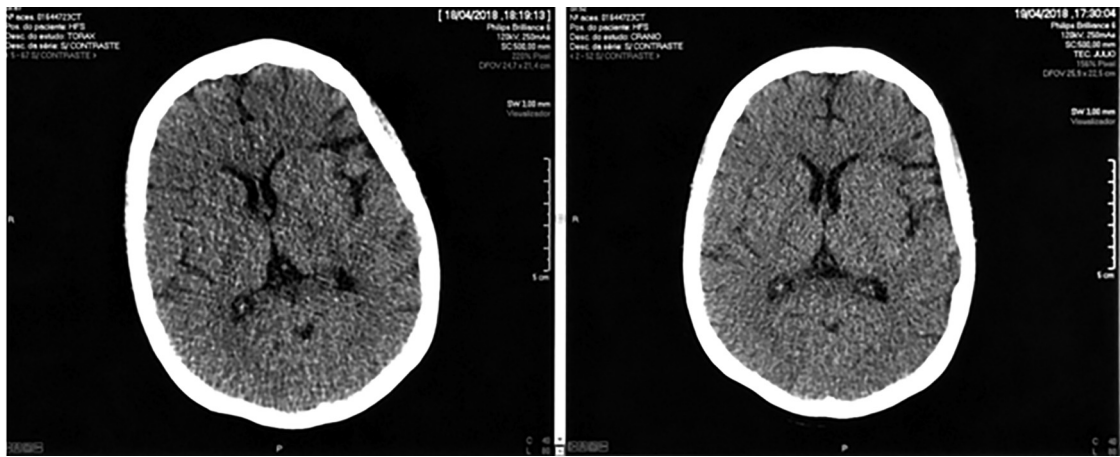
Computed tomography (CT) scan of the cranium, on 04/18/2018 (image in the left side) and 04/19/2018 (image in the right side), showing the development of evident brain edema along the period of 24 h.
